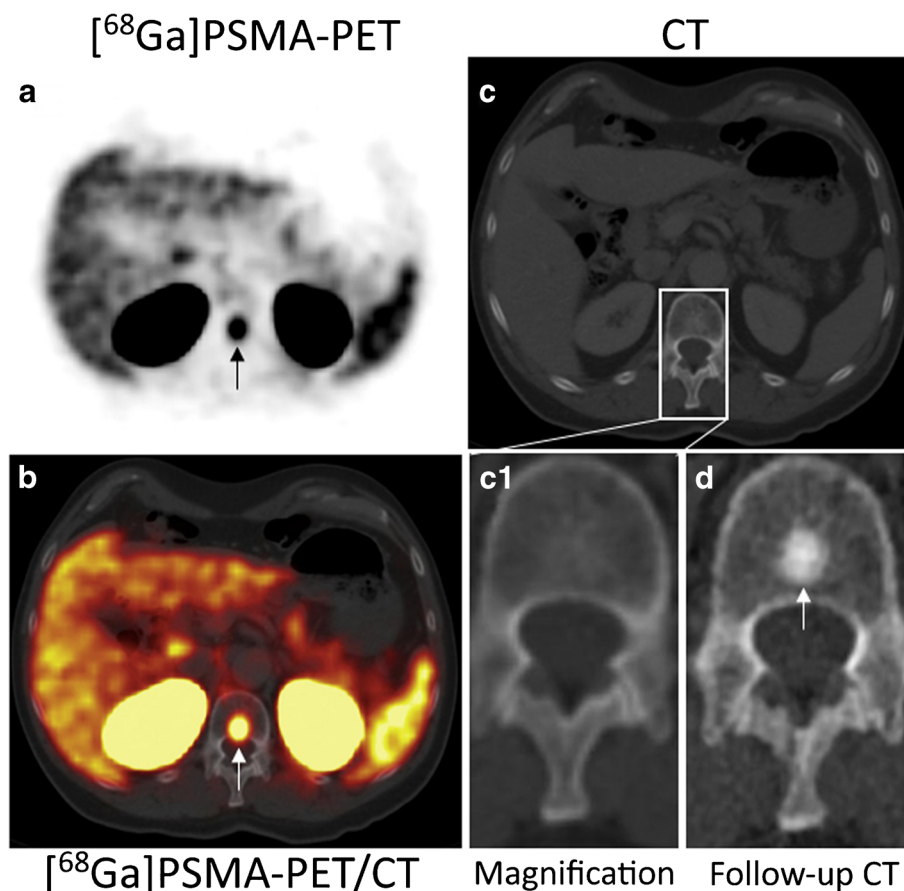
Example of a bone marrow metastasis in a lumbar vertebral body with a strong $[^{68}\text{Ga}]$ PSMA-HBED-CC uptake, which is not visible on computed tomography. a–c Example of a patient with a bone marrow metastasis and associated strong $[^{68}\text{Ga}]$ PSMA-HBED-CC uptake. a, b In the $[^{68}\text{Ga}]$ PSMA PET/CT image, a focal strong PSMA uptake is visualized in the dorsal part of the first lumbar vertebral body (black and white arrow). The metastasis had a SUV_{max} of 29.1. c On the CT image, the PET-positive metastasis does not show any changes in the calcified bone marrow structure of the lumbar vertebral body (magnification c1). The bone marrow metastasis would therefore have been missed on the CT data set. d In the follow-up CT examination 18 months later, a clear osteoblastic bone metastasis can be visualized in this area on CT.
